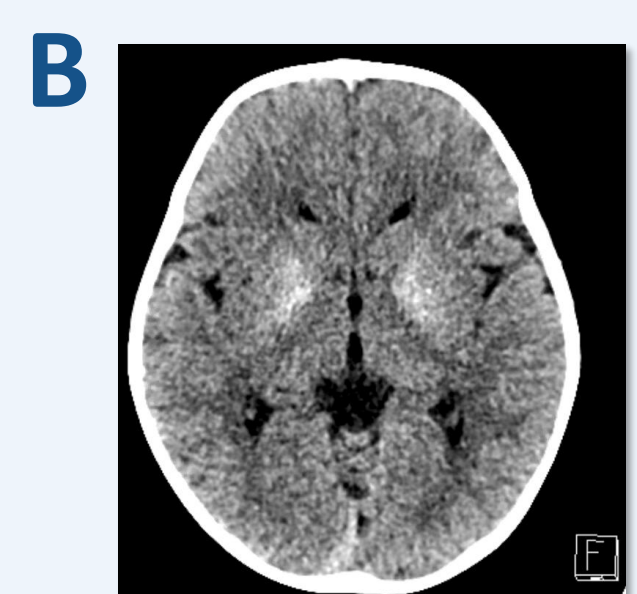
Patient imaging demonstrating phenotypic markers of SPENCD. (A) Skeletal dysplasia on radiography (B) Intracranial calcification on CT.
